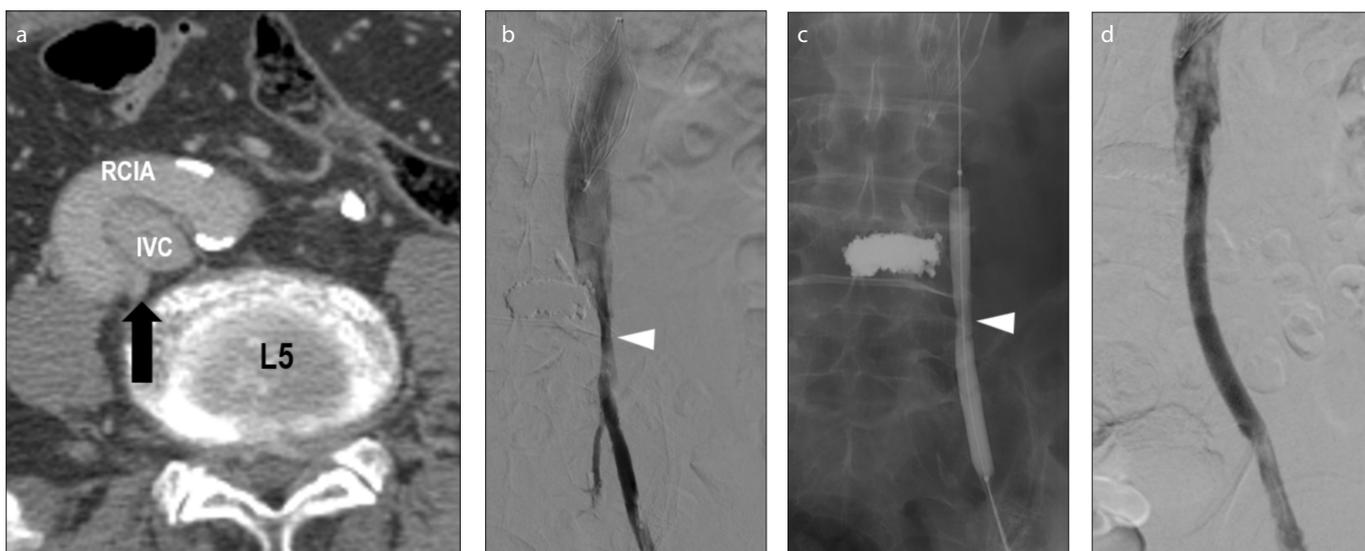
a–d. A 76-year-old man visited the outpatient department of vascular surgery with a complaint of swelling in his right lower extremity and back pain. Axial CT scan (a) with venous phase demonstrates compression of the right common iliac vein (*black arrow*) by a tortuous right common iliac artery (RCIA) and L5 vertebral body. Post-thrombolysis venogram (b) reveals severe stenosis (*white arrowhead*) in the proximal RCIA corresponding to a waist seen during balloon angioplasty (c, *white arrowhead*). A Wallstent was deployed to maintain venous outflow (d).
